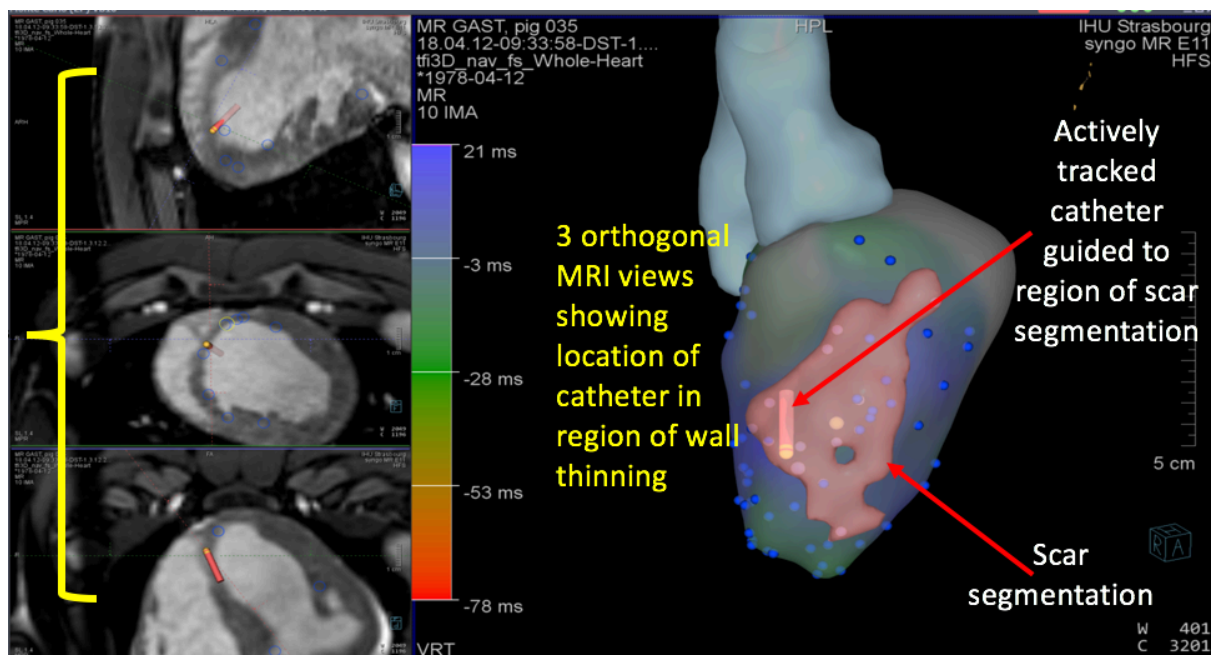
LGE-MRI images of infarct*
